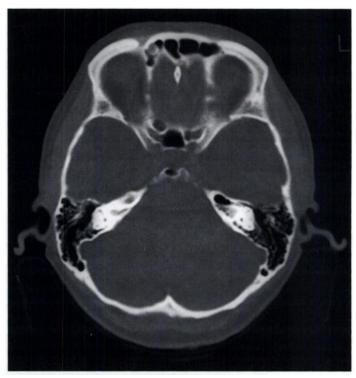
CT of the skull reveals a small nodule at the bottom of the right frontal sinus.
